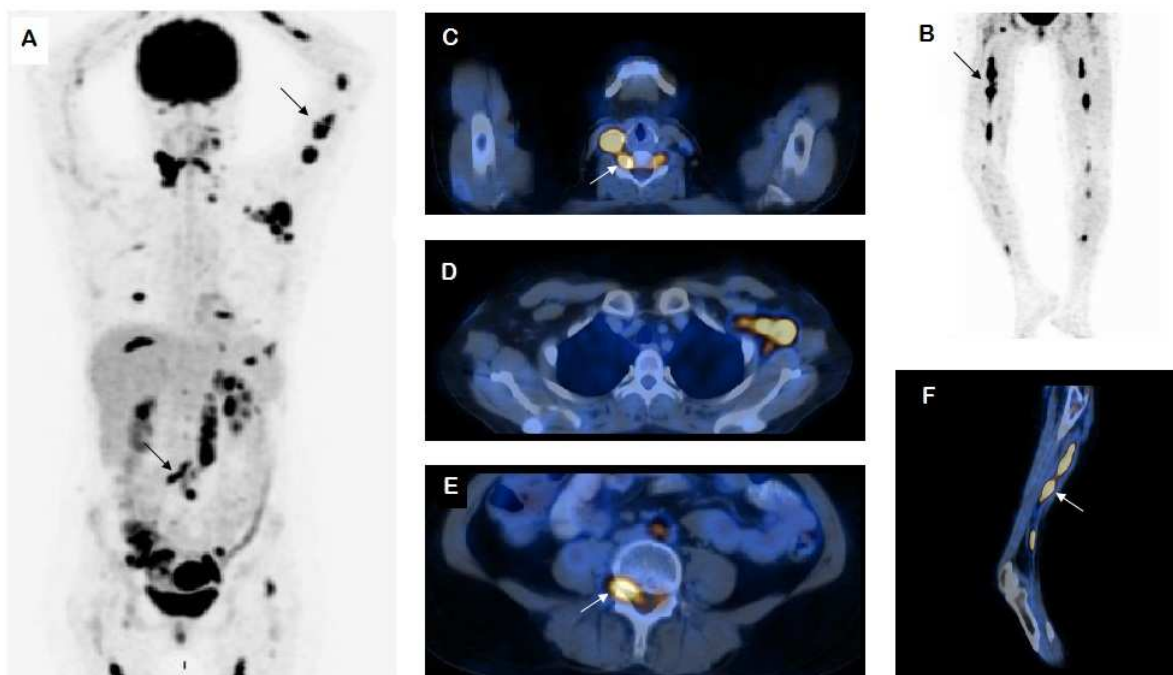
18F-FDG PET/CT scan in a non-Hodgkin's lymphoma after intrathecal chemotherapy showing poor response to treatment. Maximum intensity projection (A,B) and fused images demonstrates multiple hypermetabolic areas especially in cervical (C), left axillary (D), abdominal and pelvic lymph nodes. Moreover, there is involvement of the spinal canal and nerve roots (C,E), as well as bilateral sciatic nerve (B,F) and left arm peripheral nerve, findings compatible with neurolymphomatosis (arrows).
